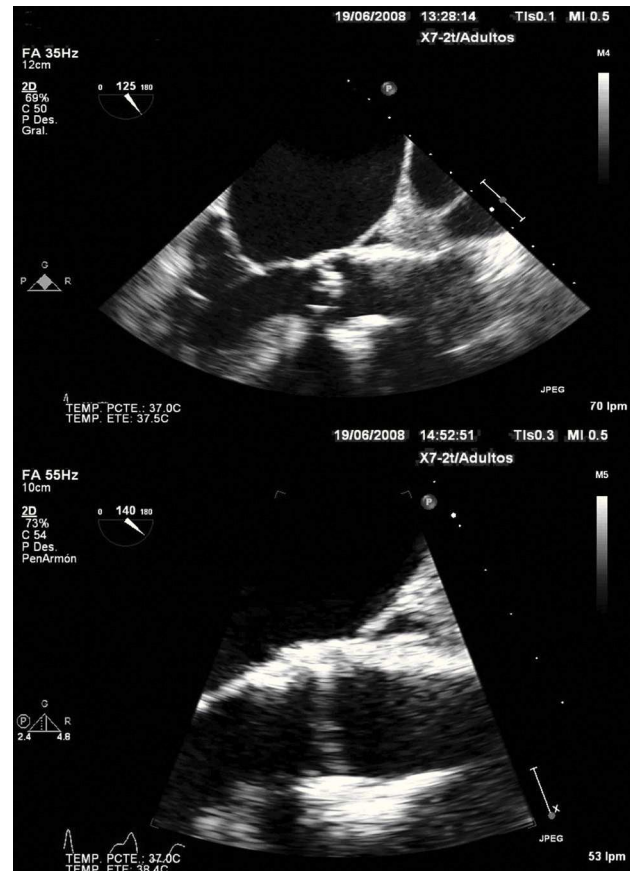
Echocardiographic images from patient 2. Top: prior to prosthesis implantation. Bottom: after implantation.
